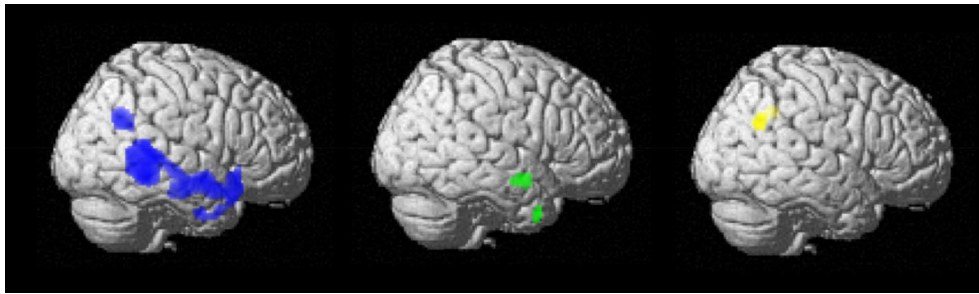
Areas of significant hypometabolism in (left) AD-BPSD as compared to AD-noBPSD (blue): bilateral superior, middle, and inferior temporal gyri; (centre) AD-BPSD as compared to AD-BPSDdeveloper (green): middle and inferior temporal gyrus; and (right) AD-BPSDdeveloper as compared to AD-noBPSD (yellow): bilateral superior temporal gyrus. AD, Alzheimer's disease; BPSD, behavioural and psychological symptoms of dementia; FDG-PET, ^{18}F -fluorodesoxyglucose-positron emission tomography; AD-noBPSD, AD patients without BPSD; AD-BPSD, AD patients with BPSD at the time of FDG-PET; AD-BPSDdeveloper, AD patients who developed BPSD after FDG-PET.
